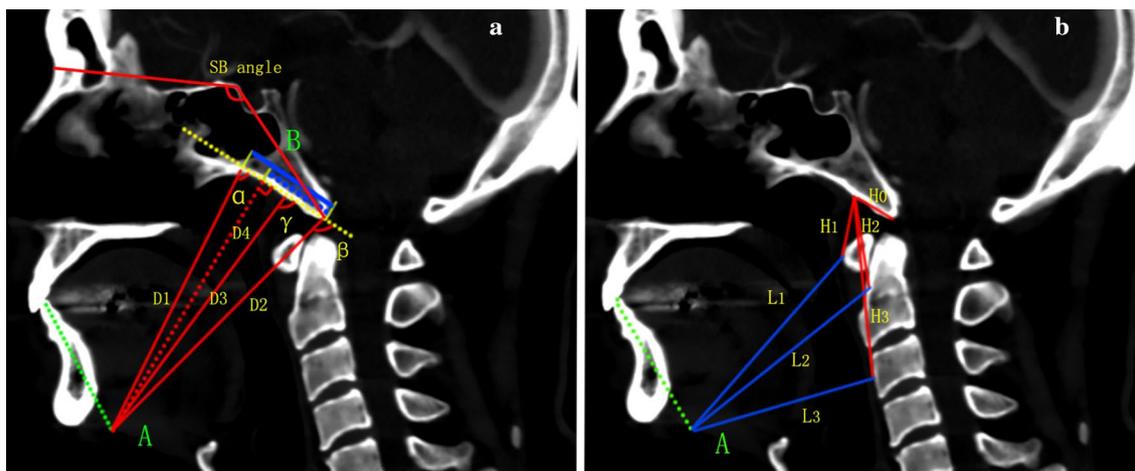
Parameters of clivus and cervical vertebrae on CT midsagittal image. Green dotted line represents maximum mouth opening. Yellow dotted line represents the tangent of extracranial clivus. Point A represents the vertex of lower incisor. a α , β , and γ are defined as the angle between the tangent of extracranial clivus and D1, D2, and D3, respectively. D1, D2, and D3 are defined as the distance between Point A and the top portion of the extracranial clivus, the bottom portion of the extracranial clivus, and the pharyngeal tubercle, respectively. D4 represents the perpendicular distance from Point A to the tangent of extracranial clivus, and Point B is defined as the vertical
